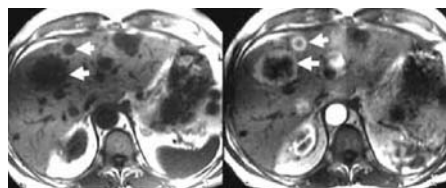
Precontrast and early post gadolinium-enhanced T1-weighted GRE (FLASH TR 170, TE 4.4, FA 70) images of hepatic metastases (arrows) demonstrate an early complete peripheral ring of enhancement.
